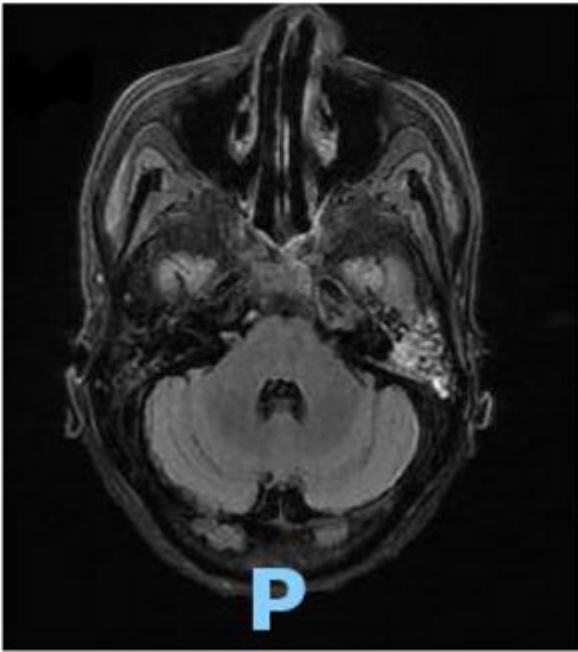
Repeat MRI showing resolution of the abscess.
